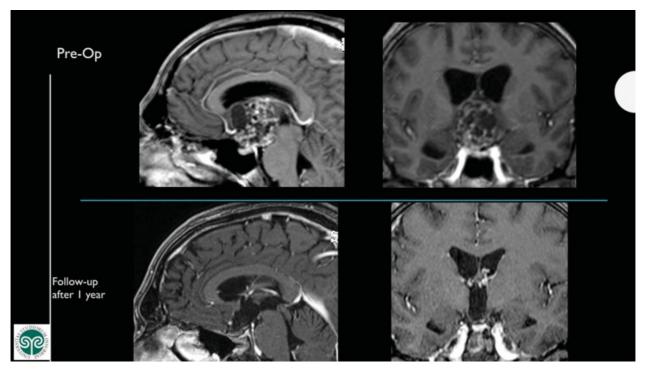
Pre- and postoperative magnetic resonance images in sagittal and coronal views.
